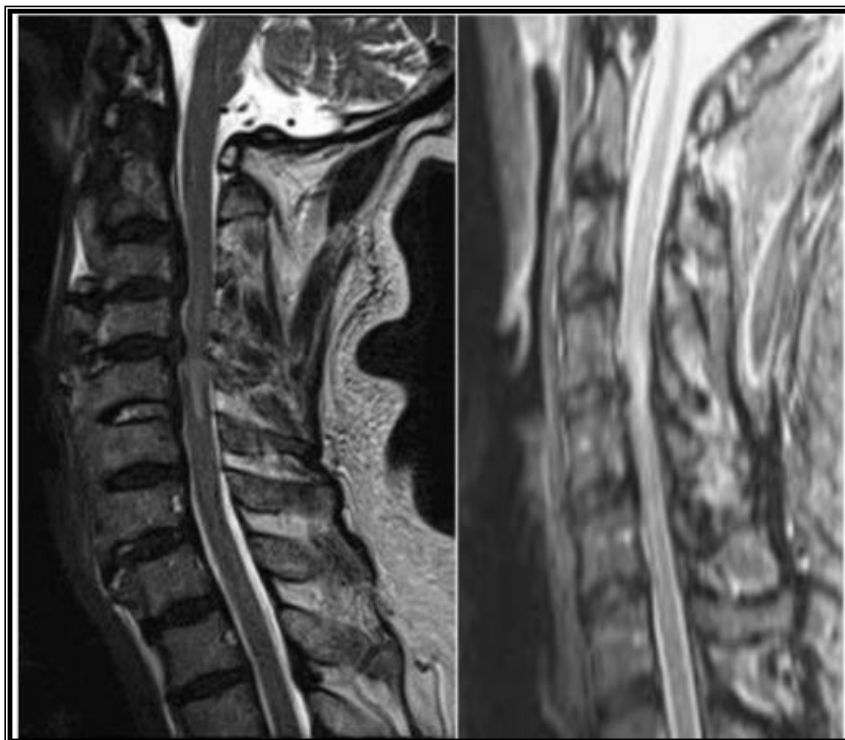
Also signal intensity grade 3 on MRI. (20).
